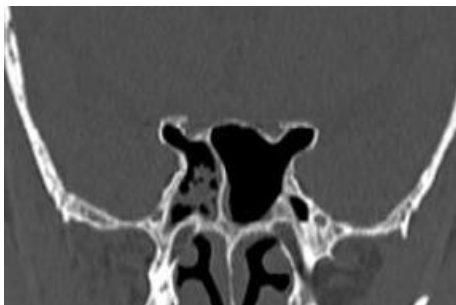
Coronal CT scan showing type 3 optic nerve on both sides with intersphenoid septa attaching to right optic canal.
